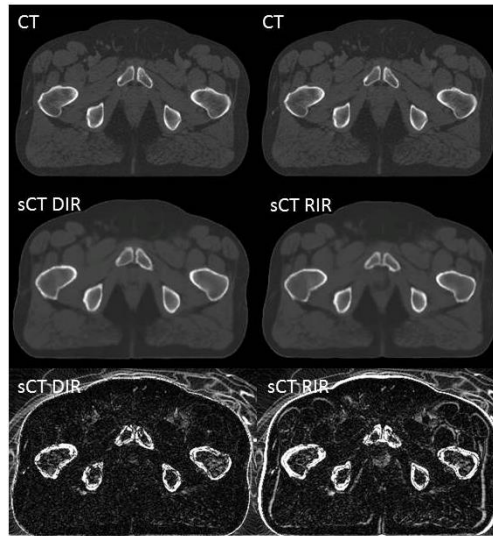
The CT (top) and DIR and RIR sCTs (middle) and their difference maps between the CT and respective sCTs (bottom) for a single anal cancer patient, with matched windowing and levelling for the CT, and sCTs and also for the difference maps.
